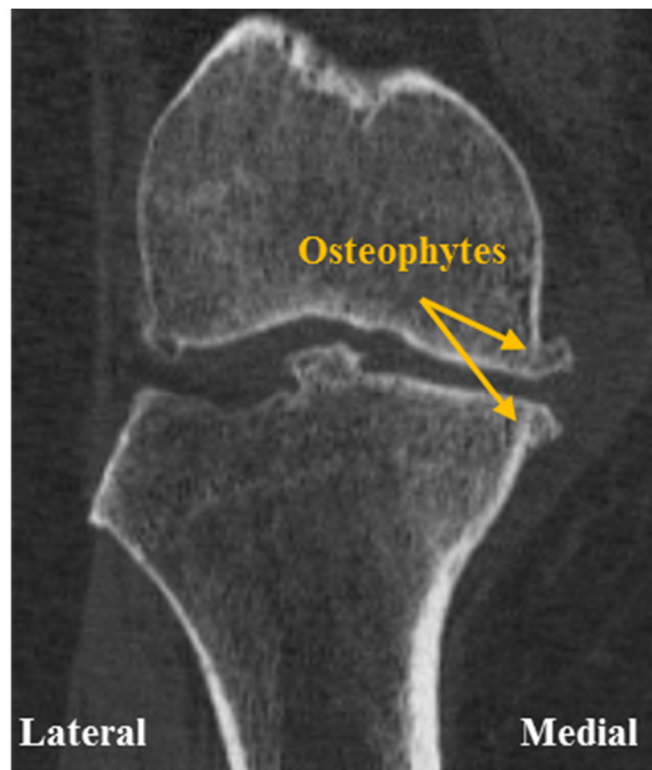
Coronal section of a CT image showing presence of medial osteophyte at the distal femur and proximal tibia.
